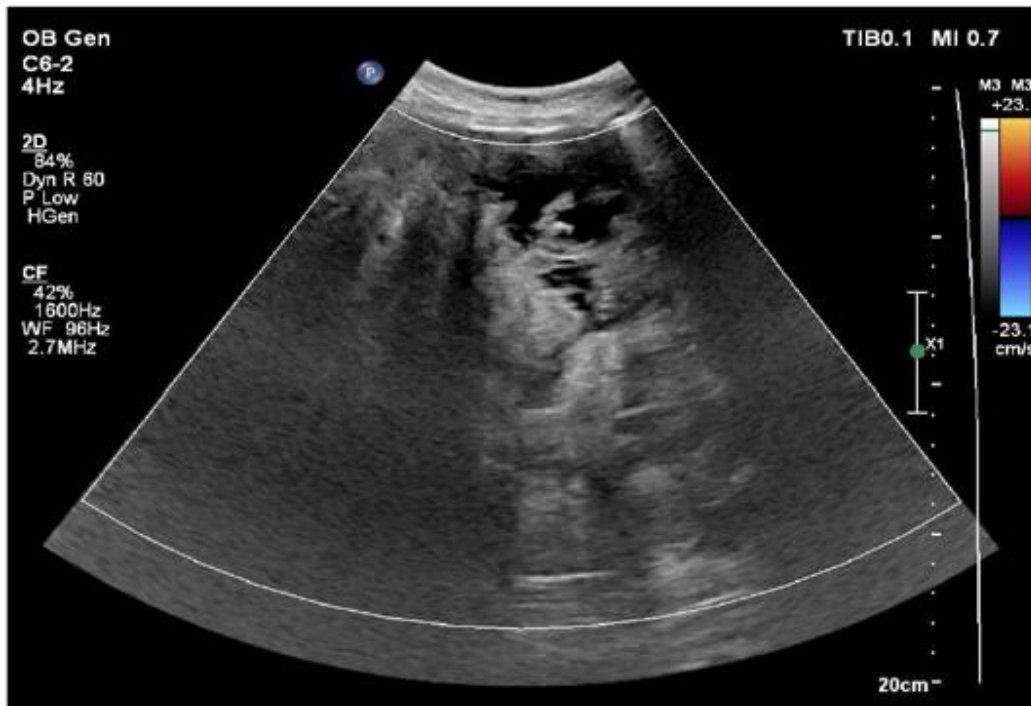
Ultrasound result showed the presence of a solid mass.
